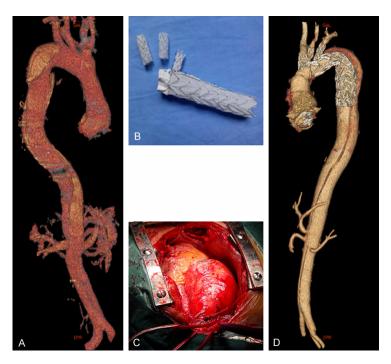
Representative patients with AAD before and after surgical repair of the total aortic arch with covered stents. A. Reconstructive CTA images of the aorta before the surgical repair. B. Covered stents for the main branches of the aorta and the aortic arch. C. Surgical procedure with CPB and antegrade cerebral perfusion. D. Reconstructive CTA images of the aorta after the surgical repair.
